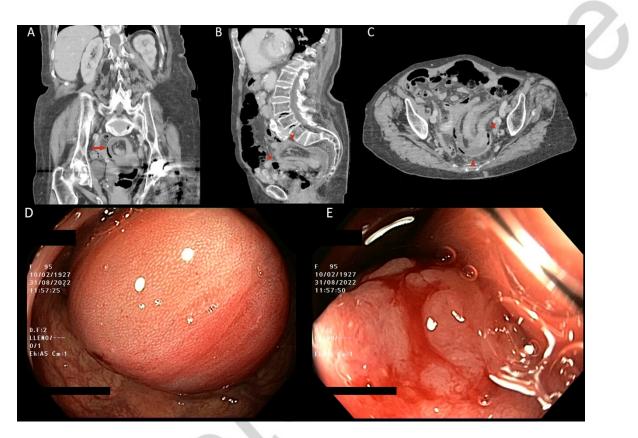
Abdominal CT scan. Coronal plane (A) showing a "target sign" at sigmoid (arrow). Sagittal (B) and axial (C) planes showing a "sausage-shaped" mass corresponding to an invaginated segment of sigmoid with its mesocolon (arrowheads). Endoscopic images. A rounded mass with a smooth surface and congested mucosa occupying most of the lumen of the superior rectum corresponding to an invaginated segment of sigmoid (D). A large sessile polyp with bleeding in its center (E).
